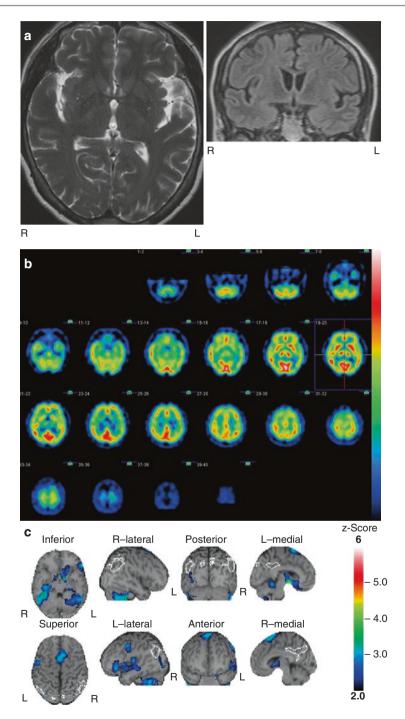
(a) MRI (T2: *left*, axial) and (FLAIR: *right*, coronal) images of PNFA. The images demonstrate asymmetric atrophy of the left Sylvian fissure. (b) ^{99m}Tc-ECD SPECT images of PNFA individual. The axial views demonstrate asymmetric hypoperfusion in the left posterior frontal–insular. (c) The result of eZIS analysis (normal healthy volunteers vs. PNFA individual). The colored areas show the regions with hypoperfusion in the PNFA individual compared with the normal healthy volunteers
